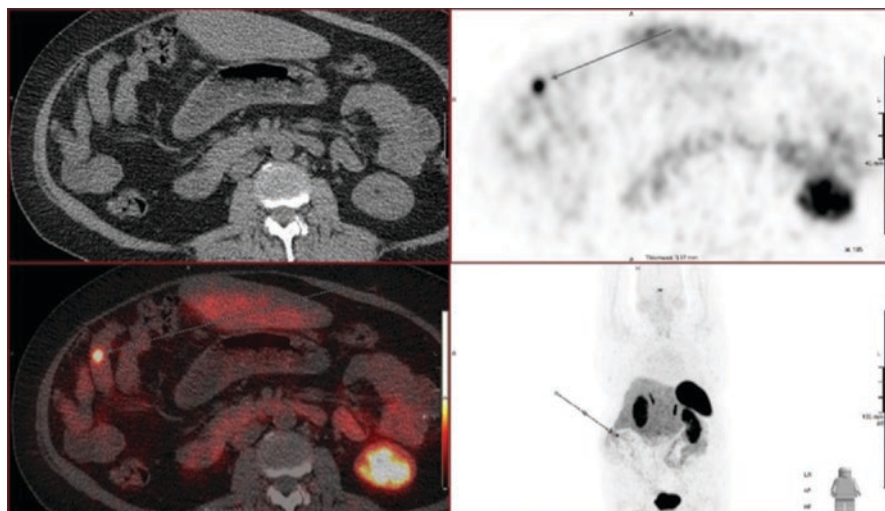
Multiplanar reconstructions of ^{68}Ga -DOTA-PET/CT scan demonstrating focal radio-tracer uptake (arrow) in a loop of small bowel representing a neuroendocrine lesion
